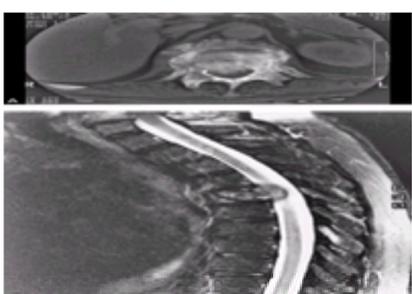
A: Computed tomographic scan showing involvement of the posterior aspect of the vertebral body resulting in partial spinal cord compression. B:
